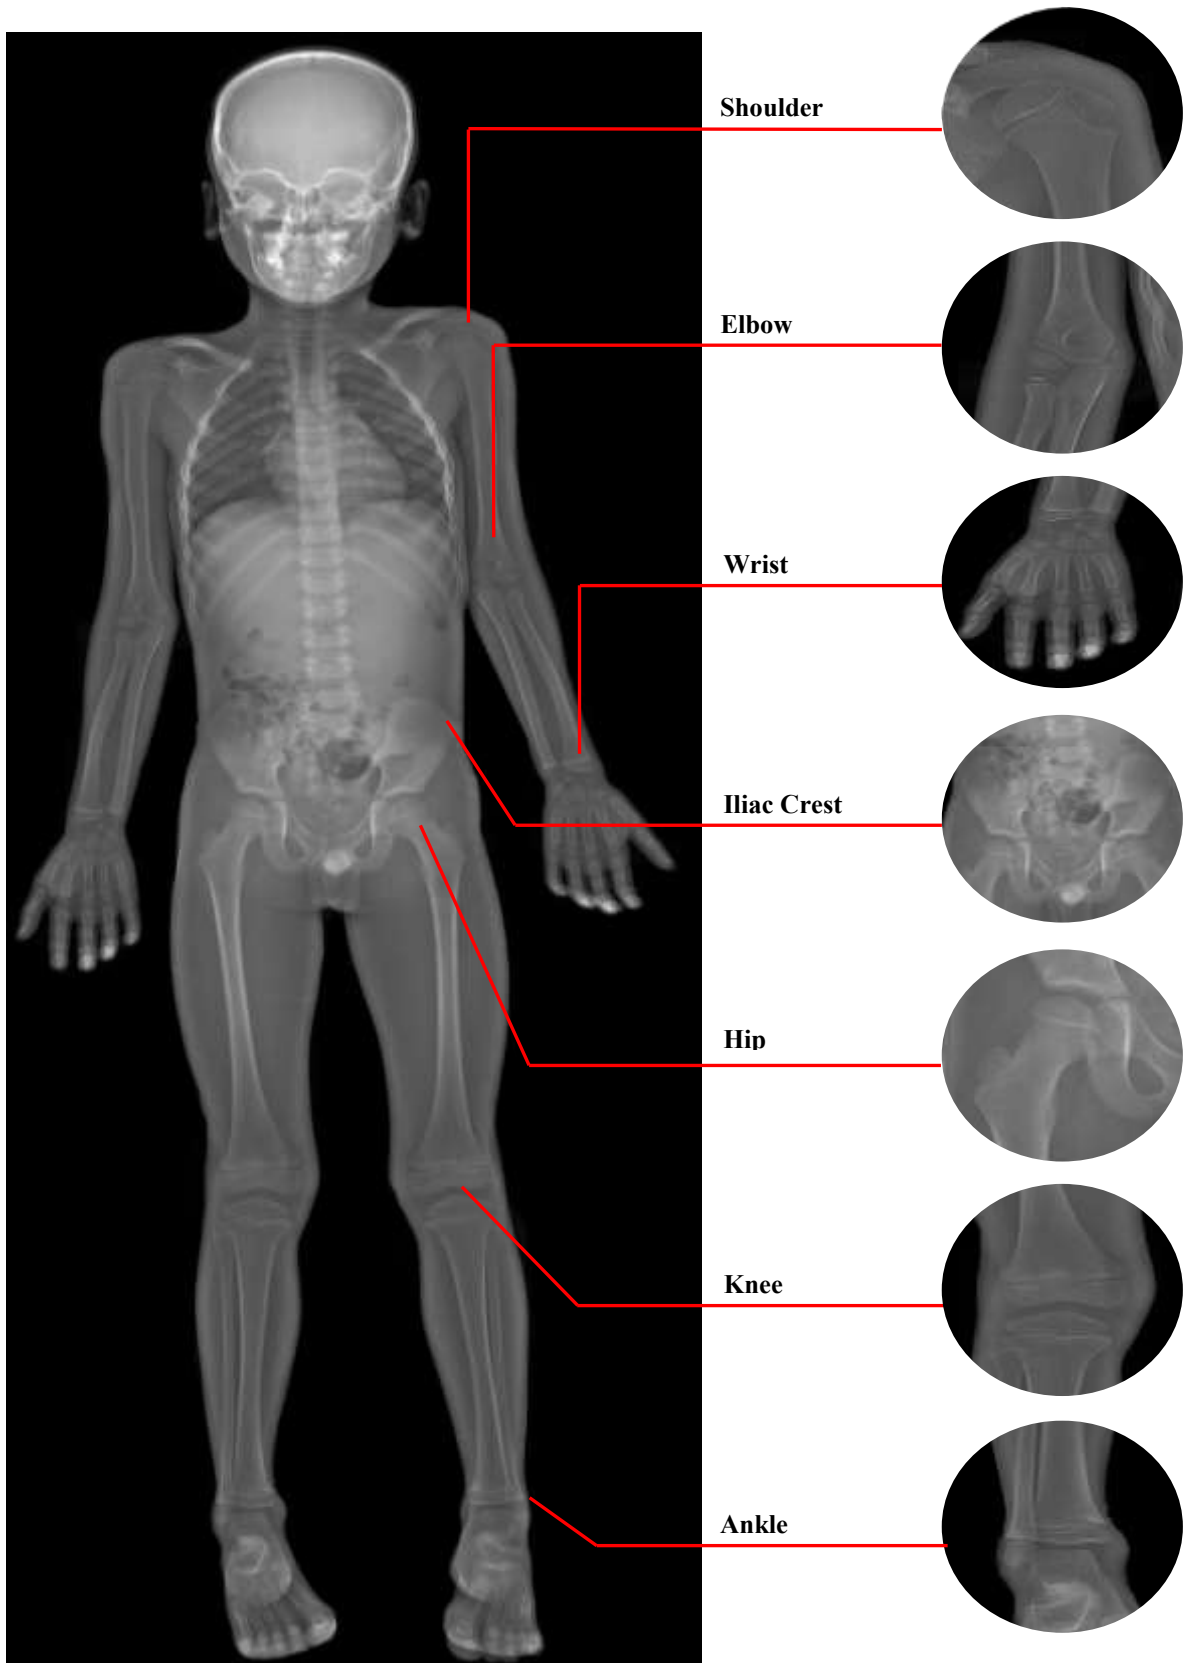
(b): Radiograph showing the epiphyses assessed in the present study. The joints represented are shoulder, elbow, wrist, hip, knee, ankle and iliac crest
